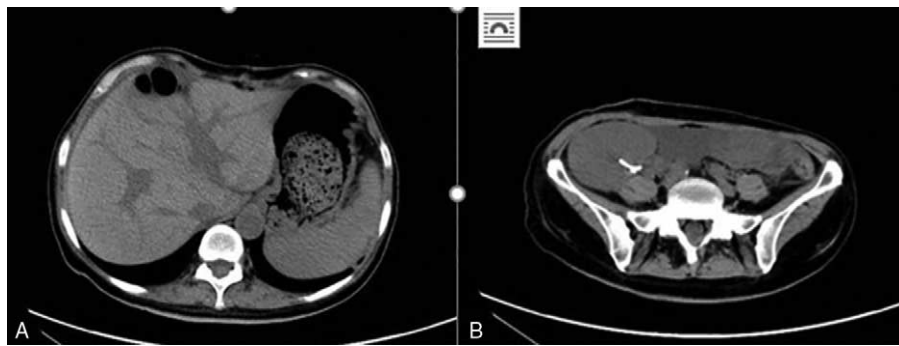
Postoperative. One month after liver and kidney transplantation, computed tomography of the liver (A) and kidney allografts (B) do not reveal any abnormal densities. CT=computed tomography.
